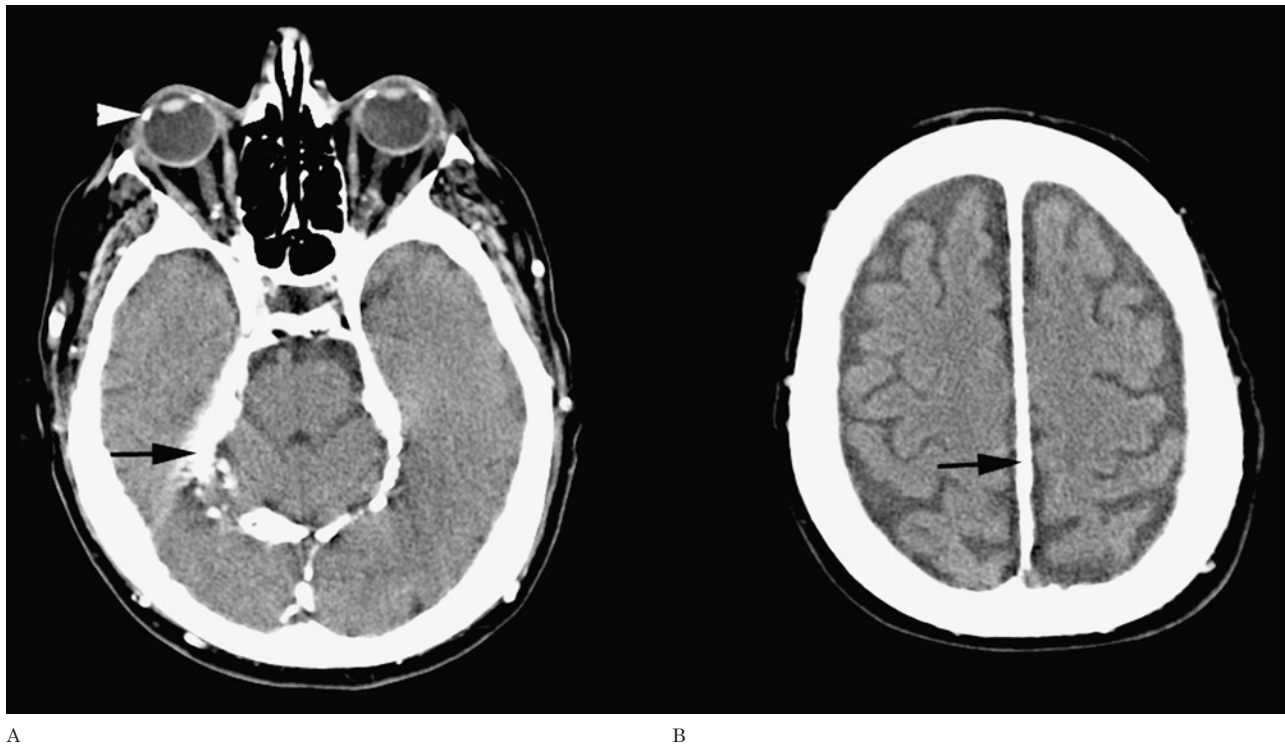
Hyperparathyroidism. Dense calcifications of the falx cerebri and tentorium cerebelli (arrows) are seen on these non-contrast CT images (A,B). Further ectopic calcifications are seen in the corneal-scleral junction (arrowhead) and the subcutaneous tissues of the scalp.
